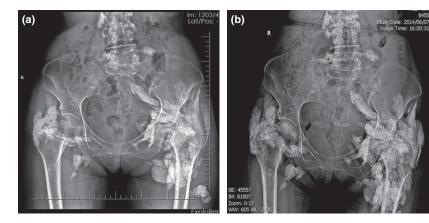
Multiple large calcifications on pelvic X-ray: (a) prior to treatment with Rituximab (2013) and (b) after treatment with Rituximab (2014).
